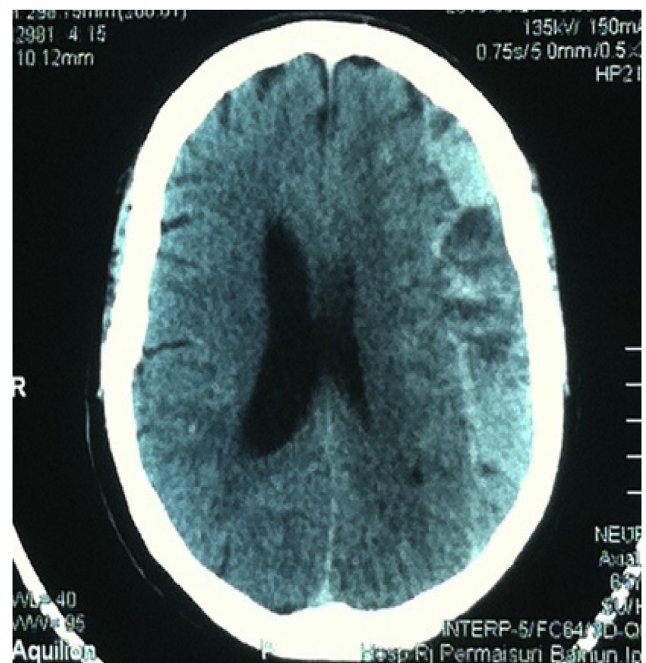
Computed tomography scan showing left acute or chronic subdural bleeding.
